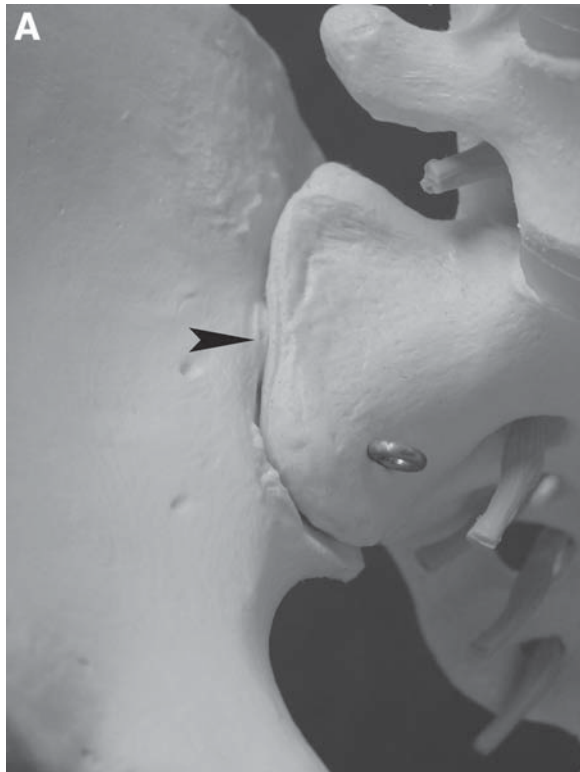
(A) Sacroiliac joint. (B) Axial CT showing the sacroiliac joint.
